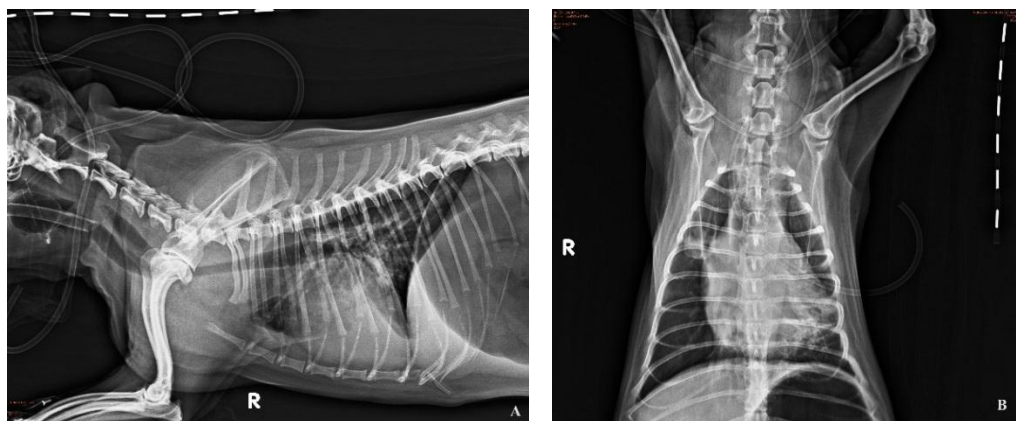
Thoracic radiographs (pre-stenting) indicated narrowing intrathoracic lumen, interstitial pattern at left caudal lobe and marked air hunger, (A); Right lateral view, (B); Ventrodorsal view.
